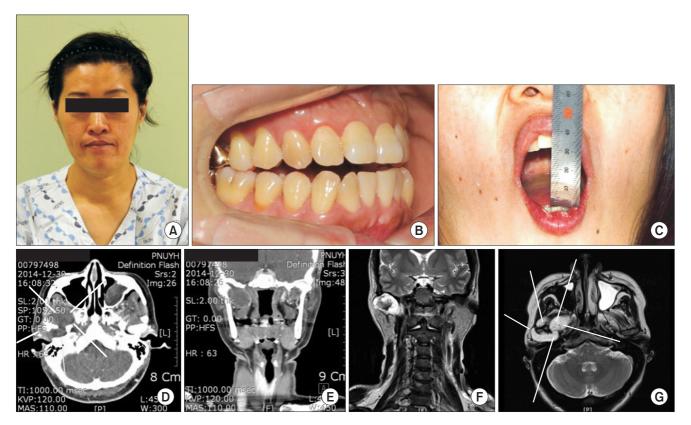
A-C. Frontal view of the patient before tumor resection. Right-side preauricular swelling, occlusal discrepancy and trismus on presentation. D-G. Low-enhanced tumor around the right condylar head on contrast-enhanced computed tomography and magnetic resonance imaging.
